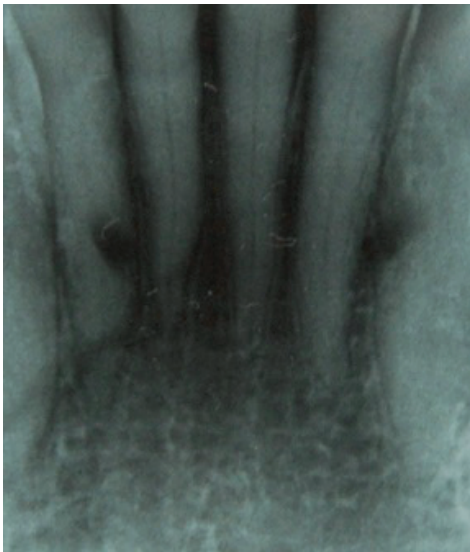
Intraoral radiograph images showing iatrogenic root damage as an outcome of the twist drill used between dental roots of lateral incisors in the mandible.
